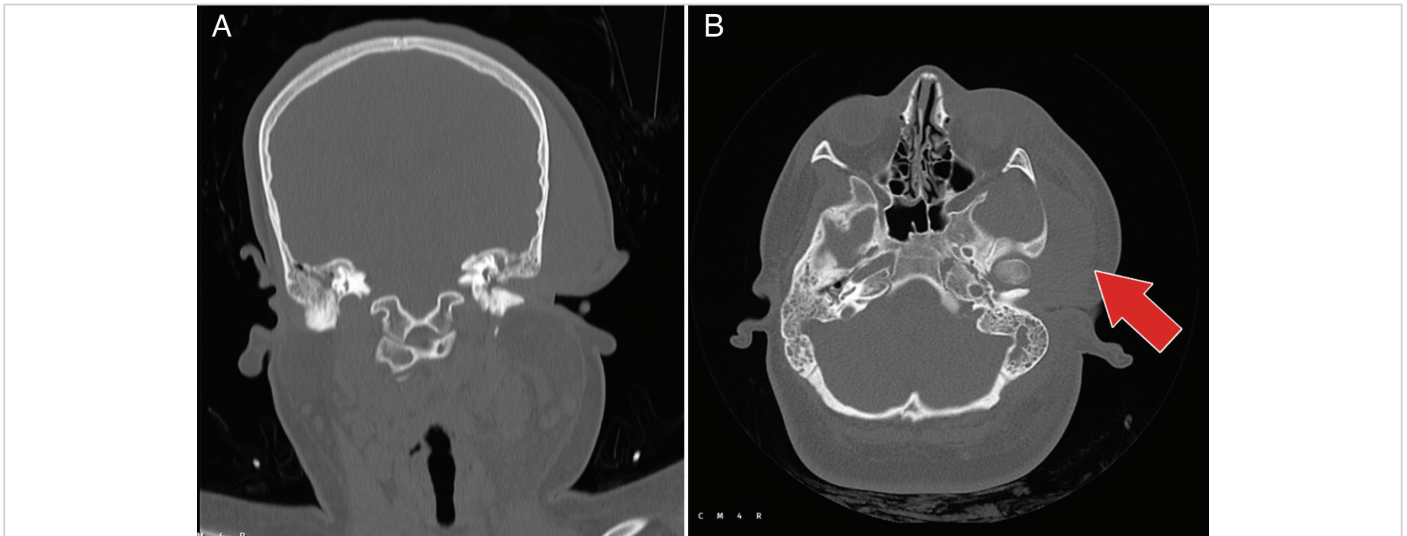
In the patient's preoperative CT scan, the left middle ear cavity was observed to be opaque with soft tissue density material (2A) compatible with acute otitis media, and further widespread edema and inflammation symptoms spreading to the left half of the face (2B)
